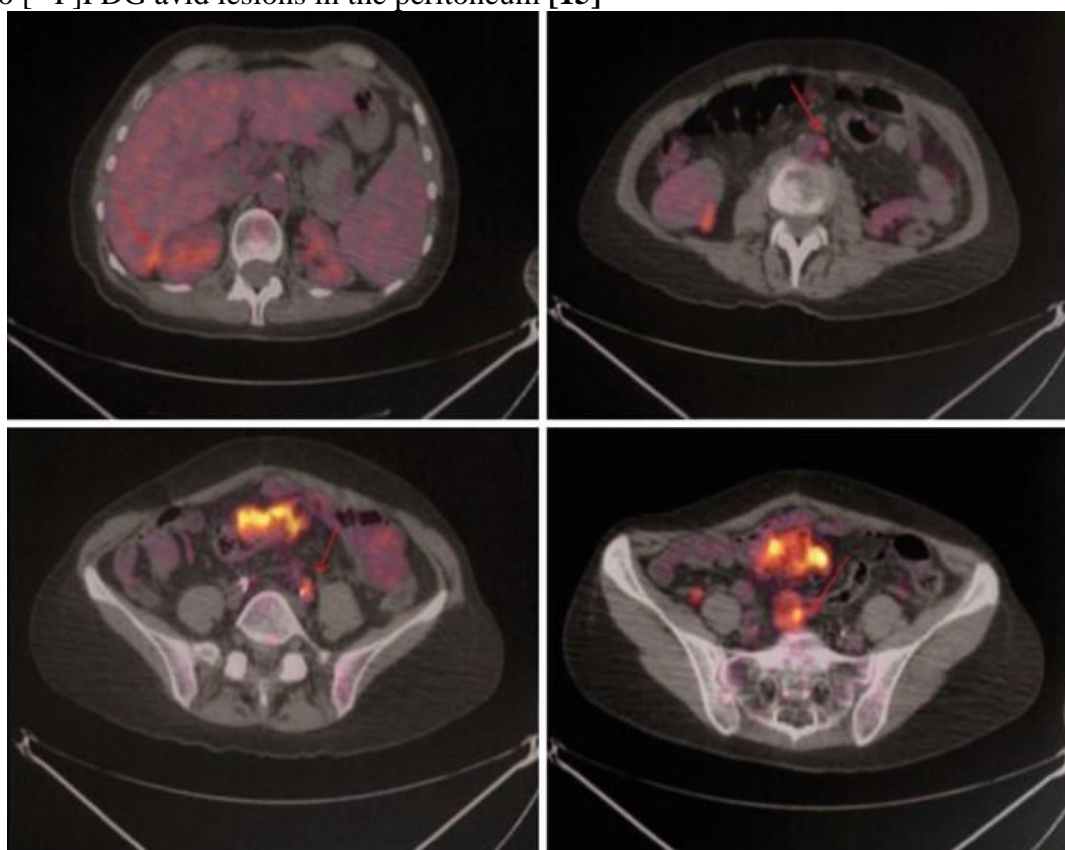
66-year-old woman, status post-treatment for ovarian carcinoma, presenting with progressively elevated CA-125 antigen and negative conventional imaging evaluation. ^{18}F FDG-PET/CT revealed several foci of increased ^{18}F FDG uptake in the peritoneum. Abnormal metabolic activity was also present in a small left paraaortic and a small left common iliac lymph node [15]
